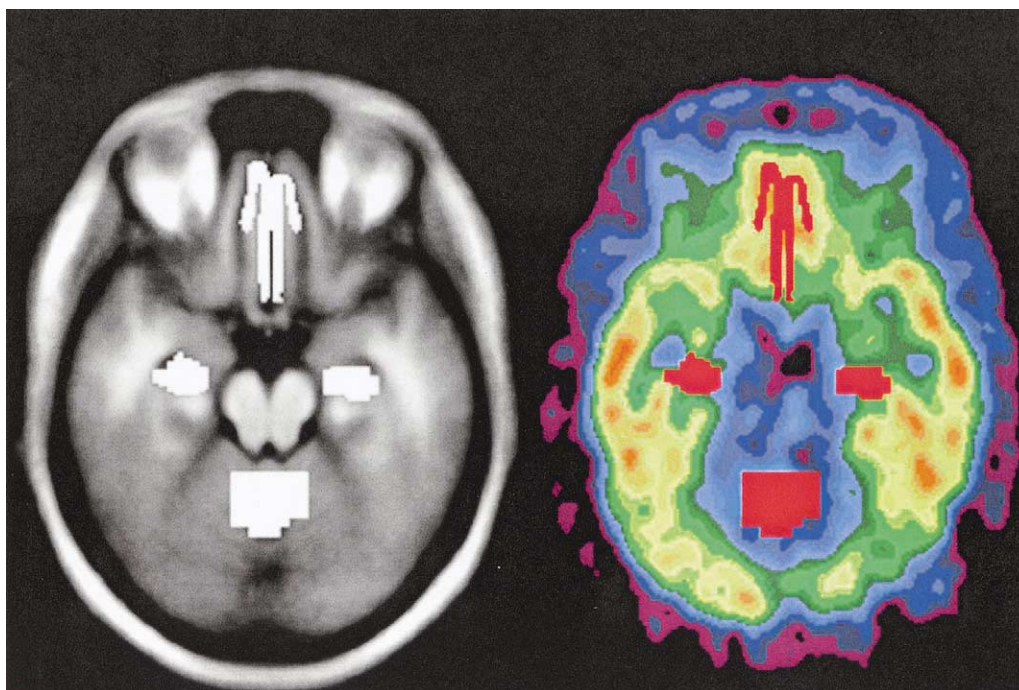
Selected slice from a PET scan of [^{18}F]altanserin (right) and coregistered averaged MRI image (left). The PET image represents the summed activity from 30 to 90 minutes after [^{18}F]altanserin injection and reconstructed at approximately 12 mm full-width half-maximum resolution. This transverse slice intersects three regions of interest: gyrus rectus (top), left and right hippocampus (mid level), and cerebellum (bottom). All ROIs are shown in white on the MRI image and in red on the PET image. Tissue time-activity curves for mathematical modeling analysis are generated by applying the ROIs to the dynamic PET frames reconstructed at approximately 5 mm full-width half-maximum resolution (FWHM). PET, positron emission tomography; MRI, magnetic resonance imaging; ROI, region of interest; FWHM, full-width half-maximum.
